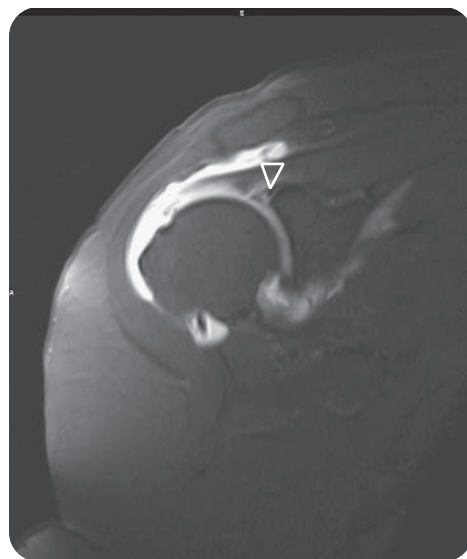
A selected coronal magnetic resonance imaging scan from a gadolinium-injected left shoulder arthrogram, demonstrating contrast extending between a torn superior labrum (*arrow*). Additionally, contrast is demonstrated in the sub-acromion space from a full thickness tear of the supraspinatus tendon.
